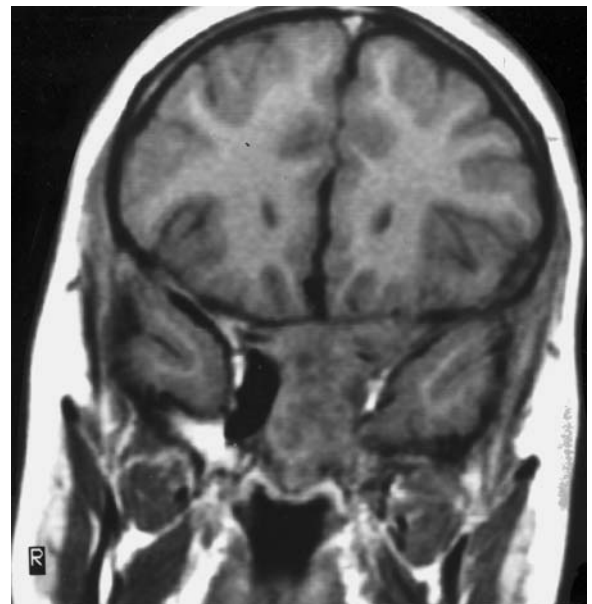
A 13-year-old boy with acute visual deficit. Diagnosis: fibrous dysplasia (Jaffé-Lichtenstein syndrome). CT (bone window): a Coronal view, showing homogeneous sclerosis of the small wings of the sphenoid bone with subsequent deformation and narrowing of both optic canals with emphasis to the left. T1-weighted MRI: b Corresponding view, where the optic nerves are not identified in the isointense signal of the pathologic sphenoid bone. (With permission of MÜLLER-FORELL and LIEB 1995b)
